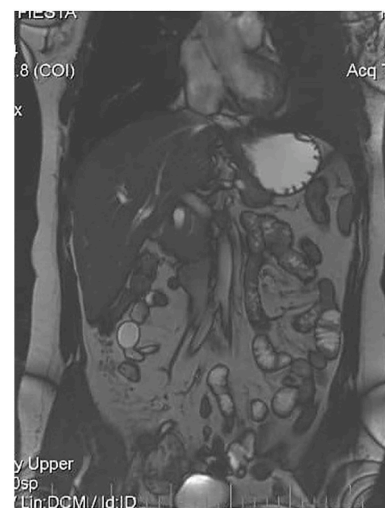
Follow-up MRI after one year (no metastasis).
